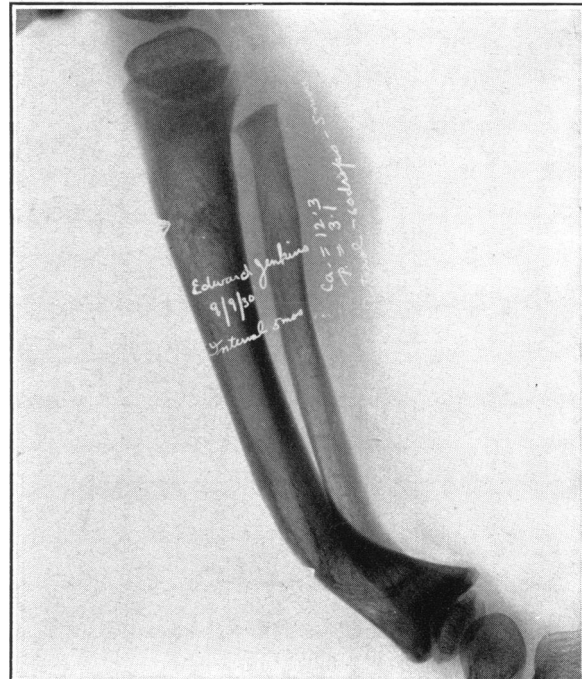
E. J. X-ray photograph of leg of same child as in Fig. 8 five months later than in Fig. 9. The sabre-shin deformity has mounted still higher as the result of continued growth at the lower epiphysis. The bending has increased. The lower end of the tibia at the time the rickets began is clearly outlined but now ends in a sharp point. Characteristic curved lines of stress extending downwards and backwards have made their appearance in the tibia below the deformity.
